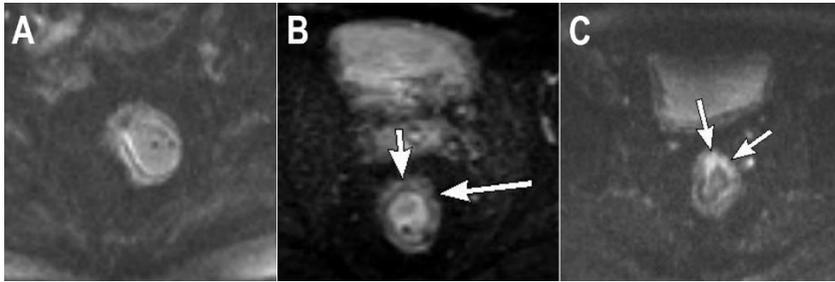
Diffusion-weighted image grading in MRI (A – Negative; B – Equivocal; C – Positive).
